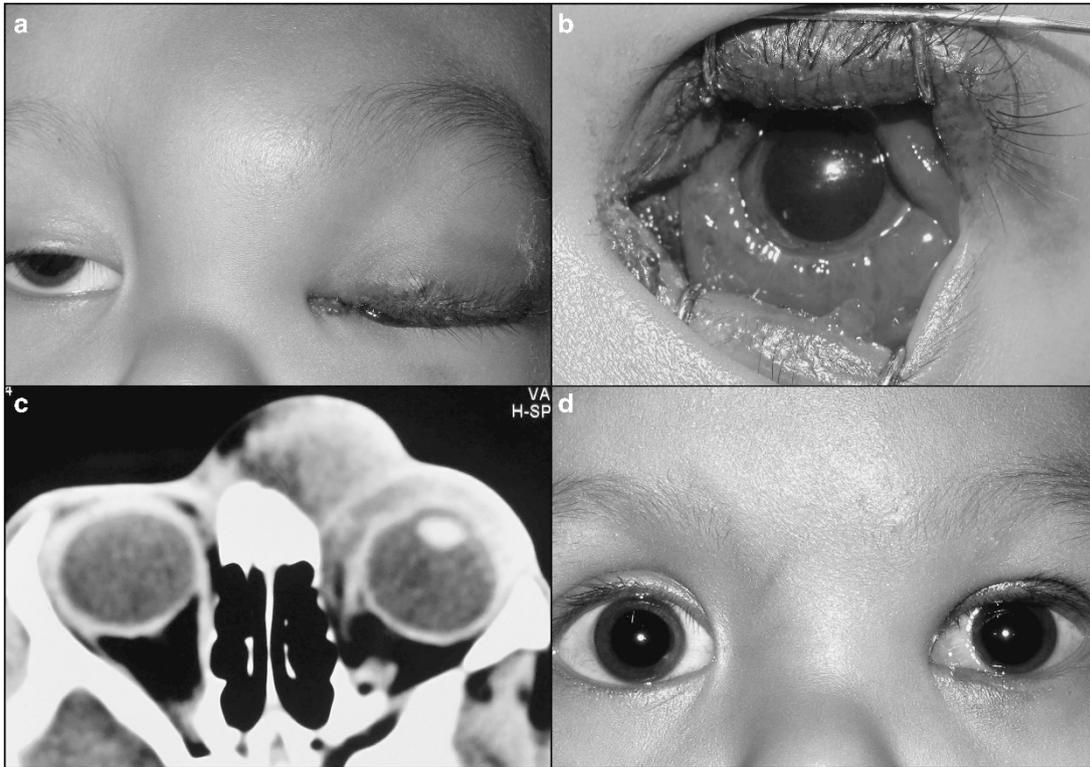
Case 1 at presentation (a) with gross upper lid swelling and a large glabellar swelling. Diffuse upper lid margin involvement with extensive conjunctival involvement and hemorrhage seen (b). CT scan shows extent of involvement (c). Appearance at last follow-up shows an excellent response (d).
